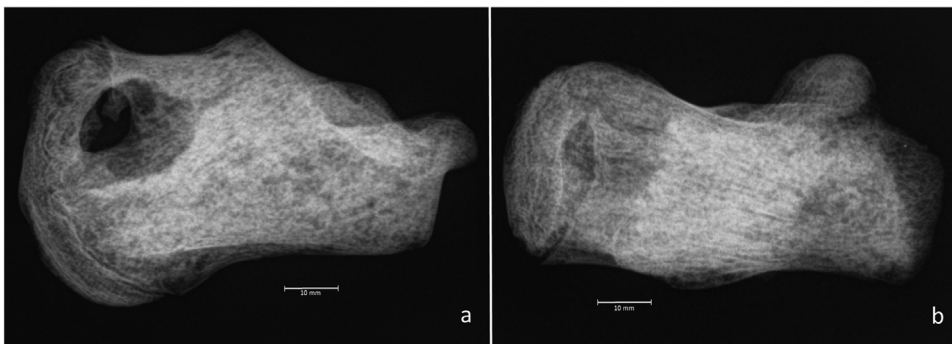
The radiograph of the medial aspect a.) indicates a sharp-margined, perforating, mildly lobulated, lytic area with no sclerotic margin. Periostotic change is evident from the radio-dense mottling on the diaphysis. The inferior aspect b.) reveals the mottling of localized periostitis but no contours of a lytic lesion.
